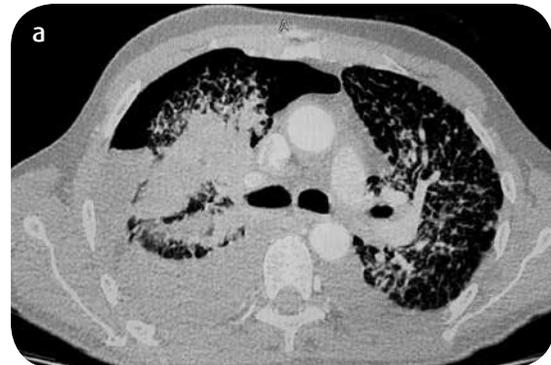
Chest CT in the pulmonary window: a) axial cuts, b) coronal and c) sagittal reconstructions: mass of right parahilar location and spiculated contours associated with multiple micronodular opacities and miliary distribution in both lung parenchyma. In the axial section, in addition, a right pneumothorax chamber is identified.
